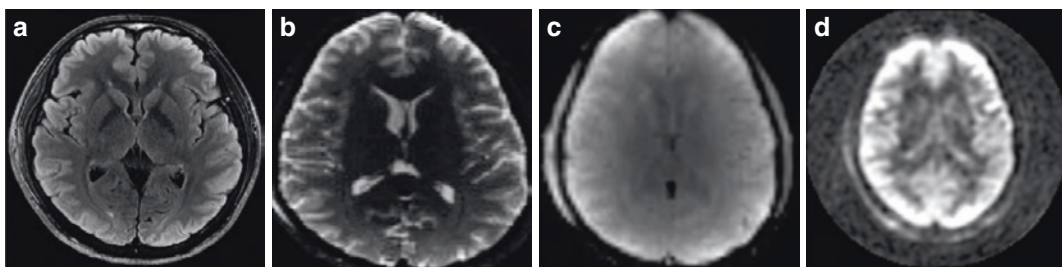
MRI findings in patients with mTBIs. Transverse T_2 -weighted FLAIR MRI (a); DTI (b); BOLD imaging (c); ASL imaging (d)
